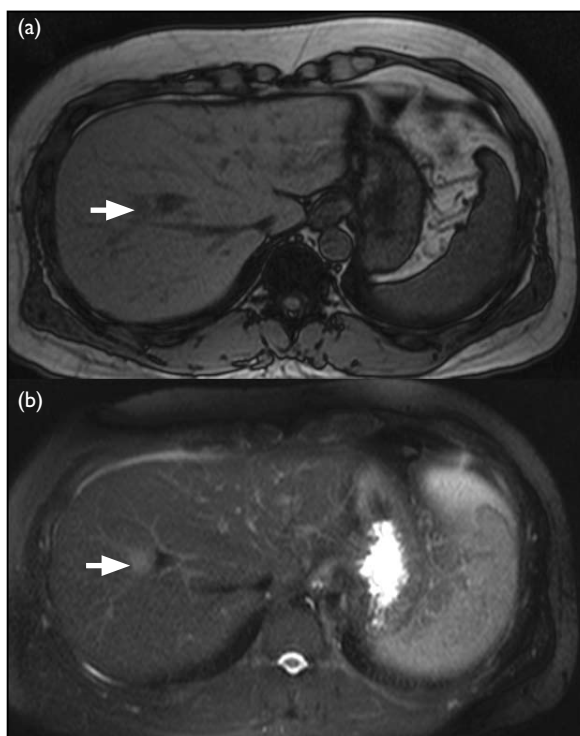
(a) T1-weighted magnetic resonance image of the liver showing a hypointense lesion (arrow), and (b) T2-weighted magnetic resonance image showing that the lesion appears hyperintense (arrow)
